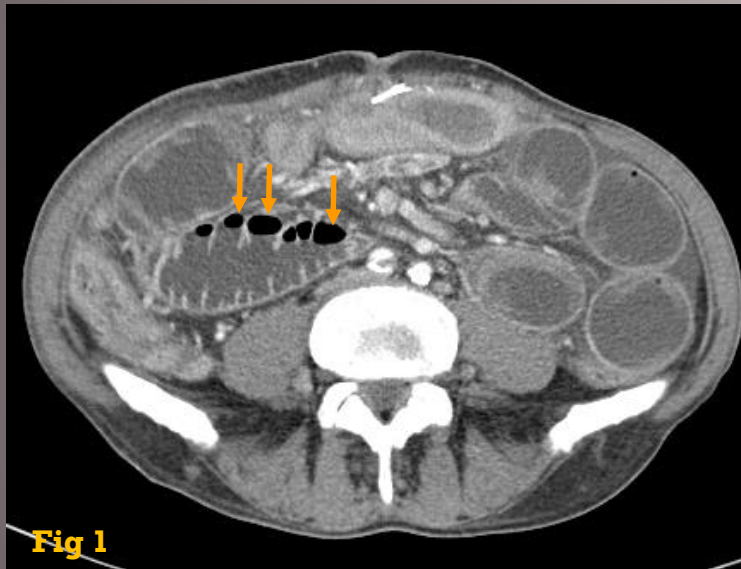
Abdominal CT of a patient in which the folds of the small bowel are widened and air bubbles become trapped in a stepladder configuration on the ventral side, mimicking pneumatosis (arrows). This is the string of pearls sign in a patient with small bowel obstruction.
